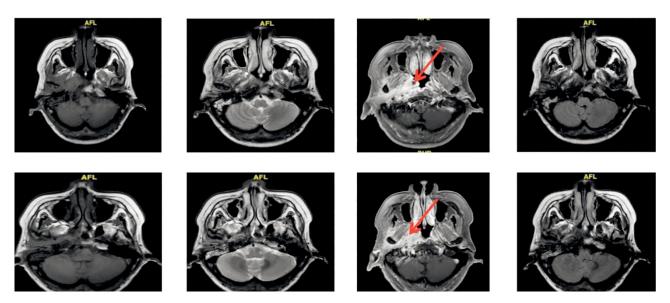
MRI images, axial cuts showing diffuse enhancing soft tissue lesion involving the right masticator, right parapharyngeal and retropharyngeal space.
